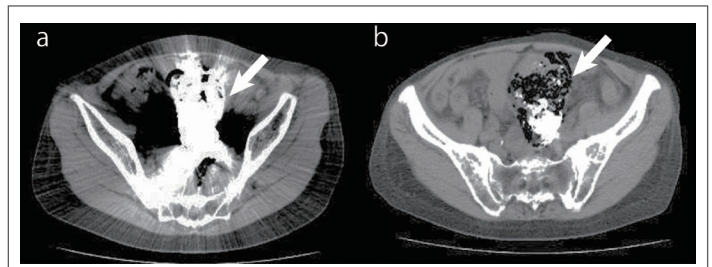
Abdominal computed tomography at admission for 66-year-old woman with perforation of the large intestine after upper gastrointestinal series with barium: a) Barium stool is retained in the sigmoid colon (arrow); b) Barium leakage in the mesentery of the sigmoid colon and intramesenteric emphysema are observed (arrow).
